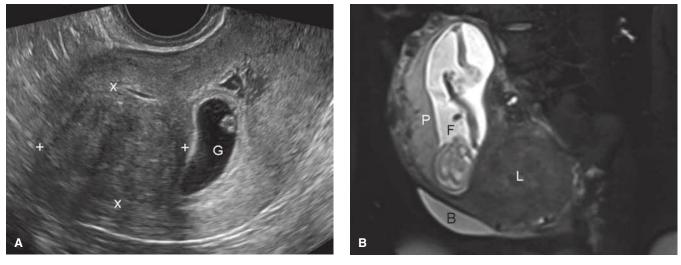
Leiomyoma imaging. A. In this sagittal view from transvaginal sonography, a large uterine leiomyoma (*calipers*) displays heterogeneous echoes and occupies the fundus. This mass lies adjacent to an early first-trimester gestational sac (*G*) that shows a yolk sac. B. MR imaging at 16 weeks' gestation shows a large leiomyoma (*L*) in the posterior uterine segment and cervix, which fills the pelvis. Associated ureteral compression and hydronephrosis required placement of a percutaneous nephrostomy tube. At term, planned cesarean delivery was done due to obstruction of the birth canal. B = bladder; F = fetus; P = placenta.
